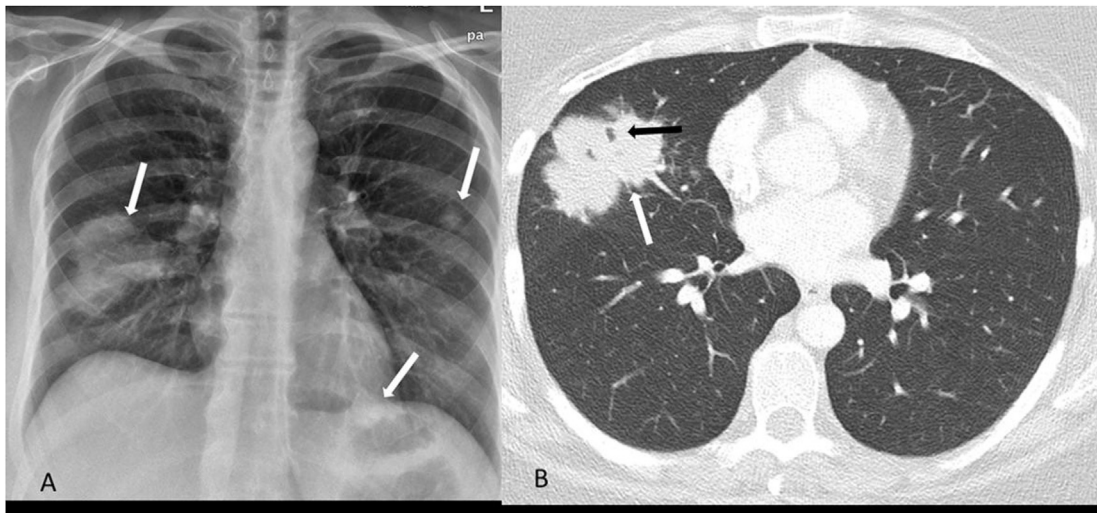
(A) Chest radiograph (posteroanterior view) reveals right mid lung zone mass (arrow) and multiple pulmonary nodules (arrows) in left lung. (B) Chest computed tomography in axial plane, in lung window, confirms presence of right middle lobe mass (white arrow), with well defined borders, lobulated outline and cavitation (black arrow).
